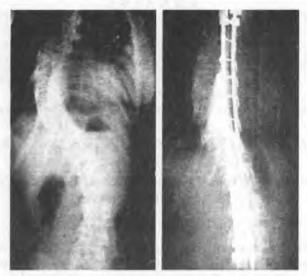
X-ray of the spine before and after operation
